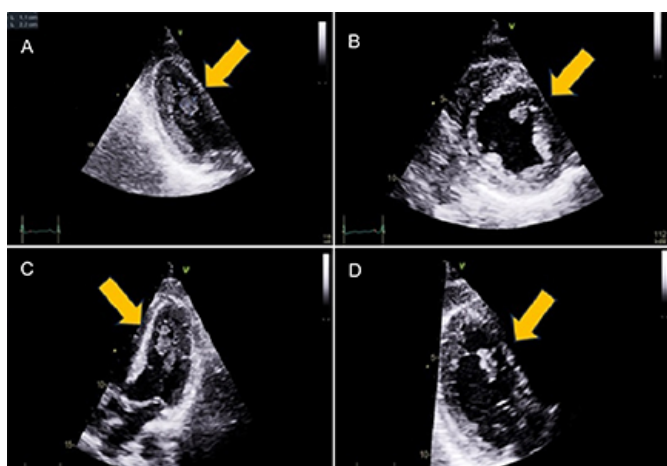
(A) Apical 3 chamber view of TTE showing large vegetation attached to papillary muscle (yellow arrow), (B) Parasternal axis view of TTE showing large vegetation attached to papillary muscle (yellow arrow), (C) Apical 4 chamber view of TTE showing large vegetation attached to papillary muscle (yellow arrow), (D) Apical 3 chamber view of TTE showing large vegetation attached near LV band (yellow arrow).
